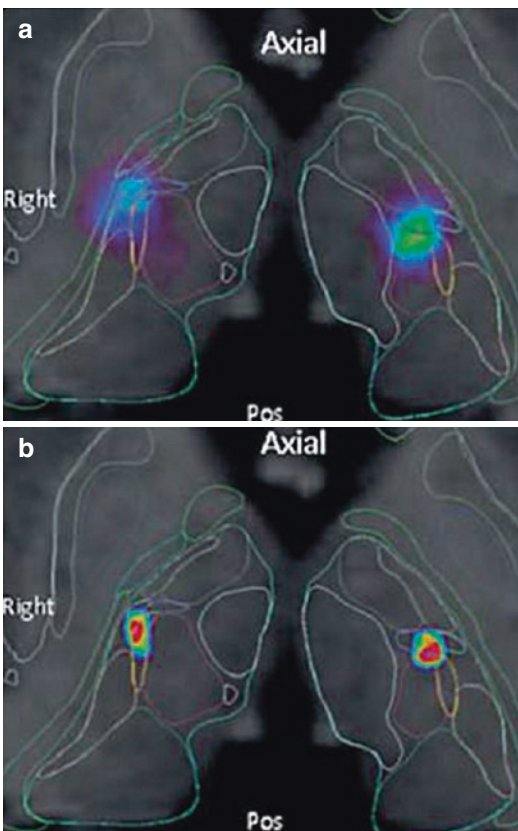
Normalized data of location of optimal tremor control in over 100 patients recorded from intraoperative stimulation overlaid to a reference atlas MRI. (a) Points are normalized using Talairach rigid approach. (b) Points are normalized using a nonlinear registration approach. One can note how focal the statistical map created from the points is on (b) compared to (a)
